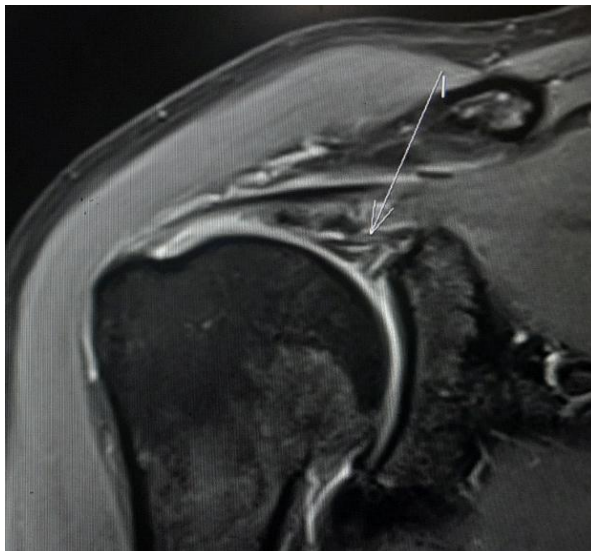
Coronal MRI Shoulder image revealing SLAP extending to long head of biceps (arrow) along with partial tear involving articular surface of Supraspinatus.
